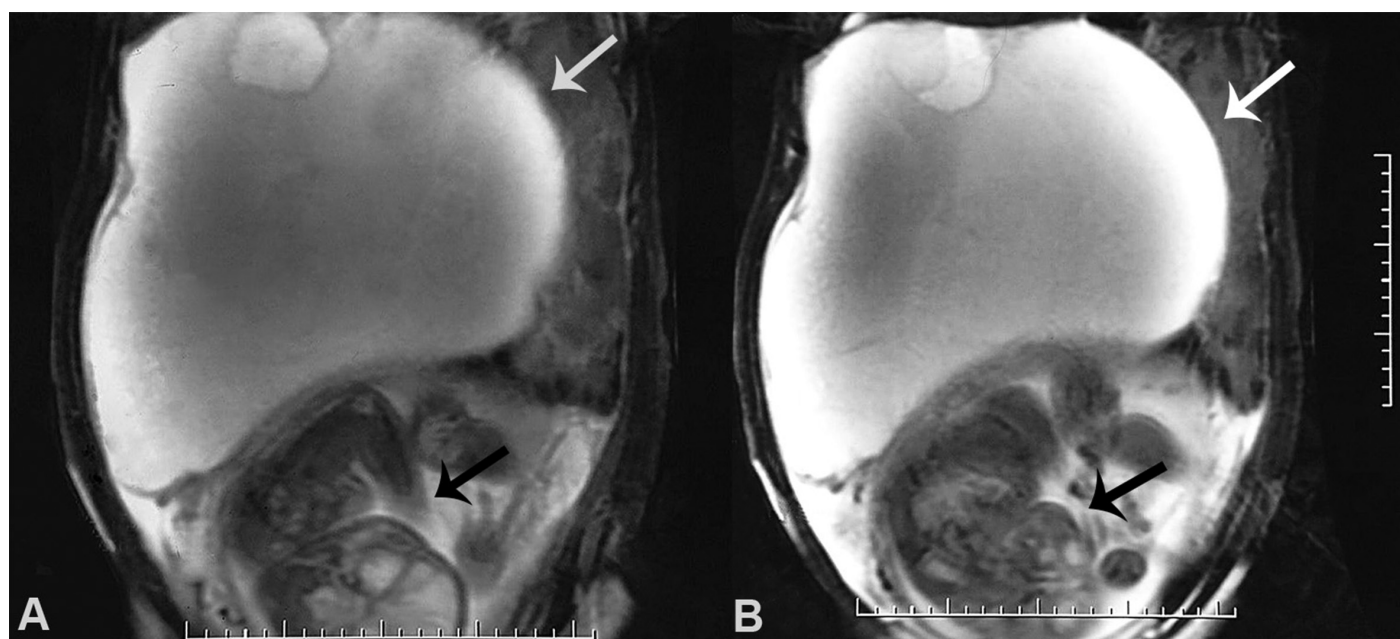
A and B - T2-weighted magnetic resonance imaging of the abdomen showing the gravid uterus with single fetus (black arrows), cephalic presentation and back to the right, and a voluminous cyst with apparent excrescence in the inferior aspect (white arrow).
